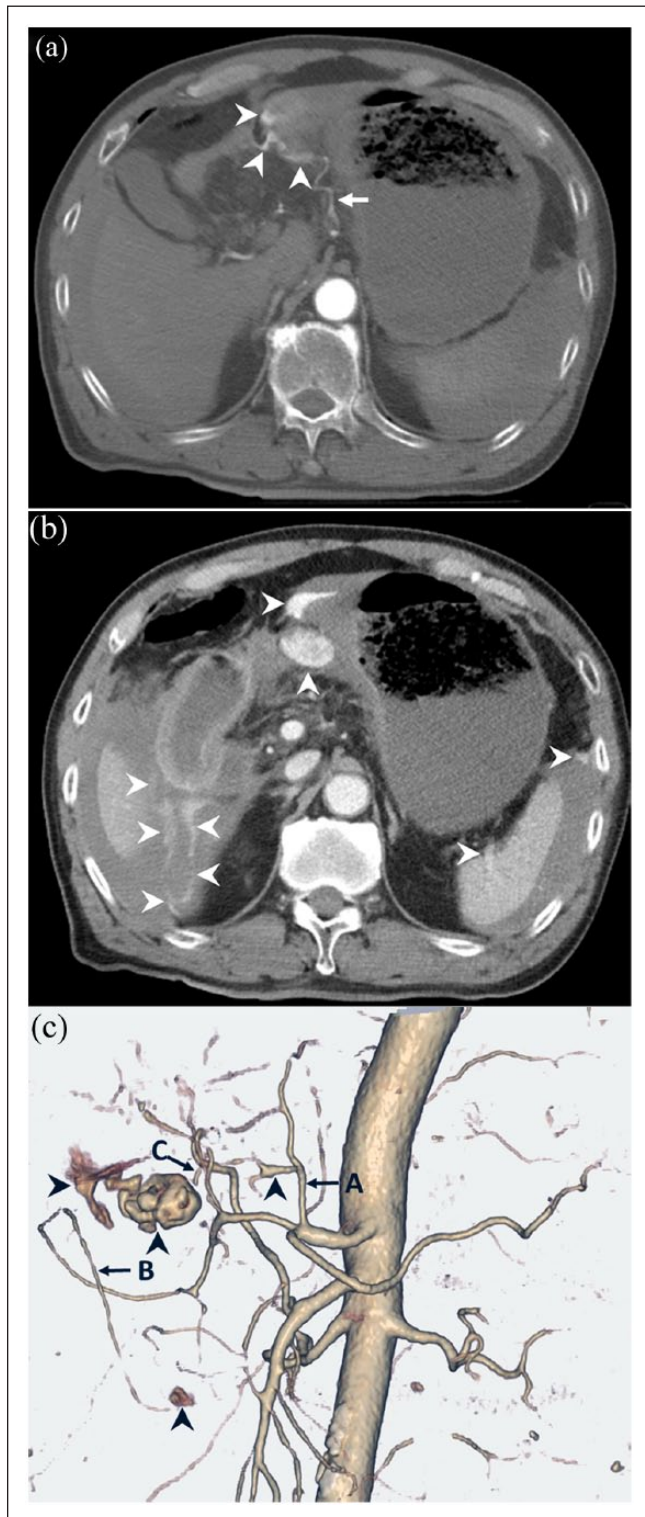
(a) Abdominal computed tomography (CT) scan, arterial phase. The arrow indicates the left gastric artery. The arrowheads show contrast medium extravasations. (b) Abdominal CT scan, venous phase. The arrowheads show extravasations spreading to the peri-stomach, left subphrenic space, and peri-hepatic space. (c) Three-dimensional volume-rendered CT angiogram. Label A represents the left gastric artery, label B represents the right gastroepiploic artery, and label C represents the right gastric artery. The arrowheads show contrast medium extravasations.
